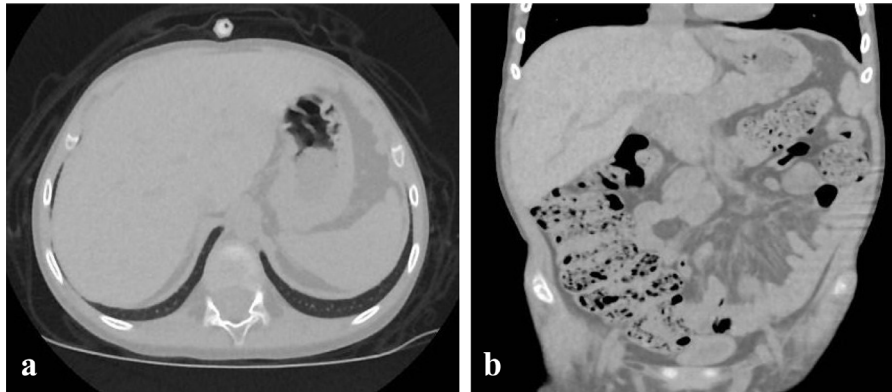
CT scan of the abdomen. (A) Axial view in lung window demonstrating the absence of free subphrenic air. (B) Coronal reconstruction of abdomen CT images in lung window shows the redintegration of intestinal walls.
